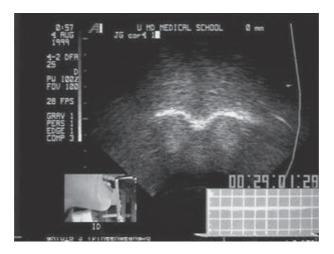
An ultrasound image of the coronal (crosswise) tongue. The upper surface has a midline groove.
